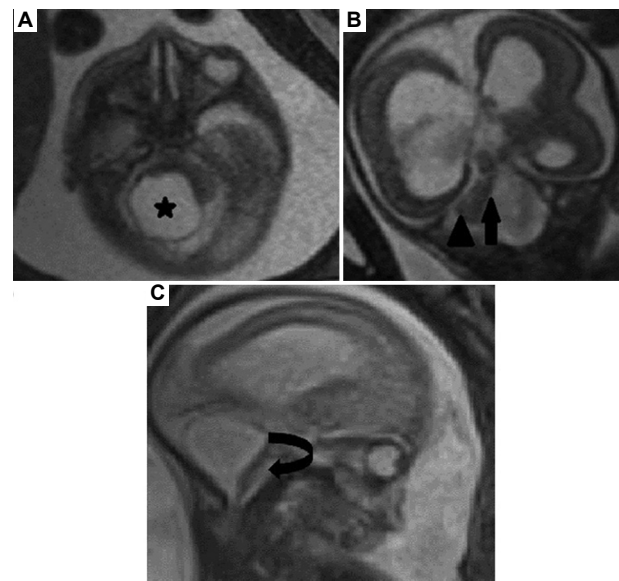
MRI images of (A) axial and (B) coronal TRUFI, as well as (C) sagittal HASTE images, demonstrate agenesis of the vermis (black arrow) and right cerebellar hemisphere (black star). Additionally, the left cerebellar hemisphere appears small and dysmorphic (black arrowhead). Notably, the pons is significantly hypoplastic for gestational age, with an absent ventral bulge (black curved arrow).
